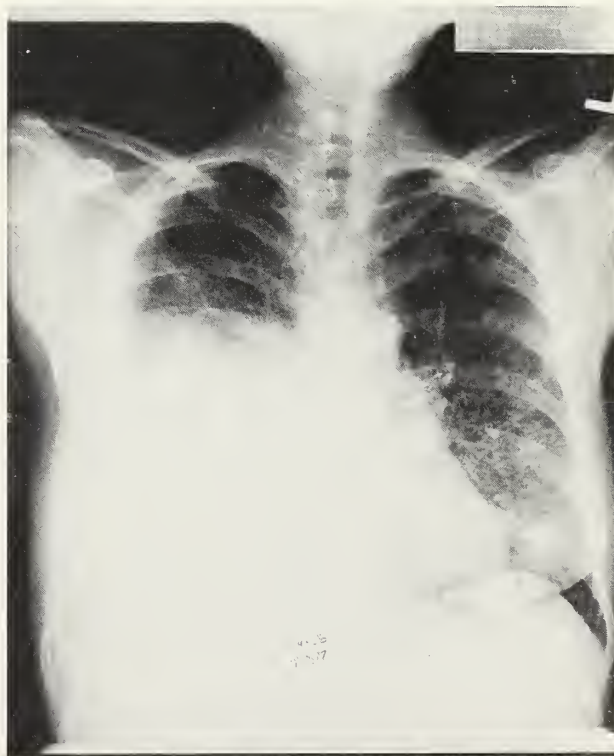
Chest x-ray shows parenchymal infiltrate at right base and considerable amount of effusion.
